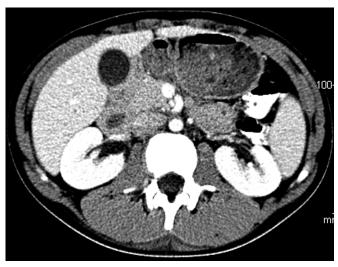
Abdominal computed tomographic scan showing "swirling" of superior mesenteric vein around the superior mesenteric artery.
